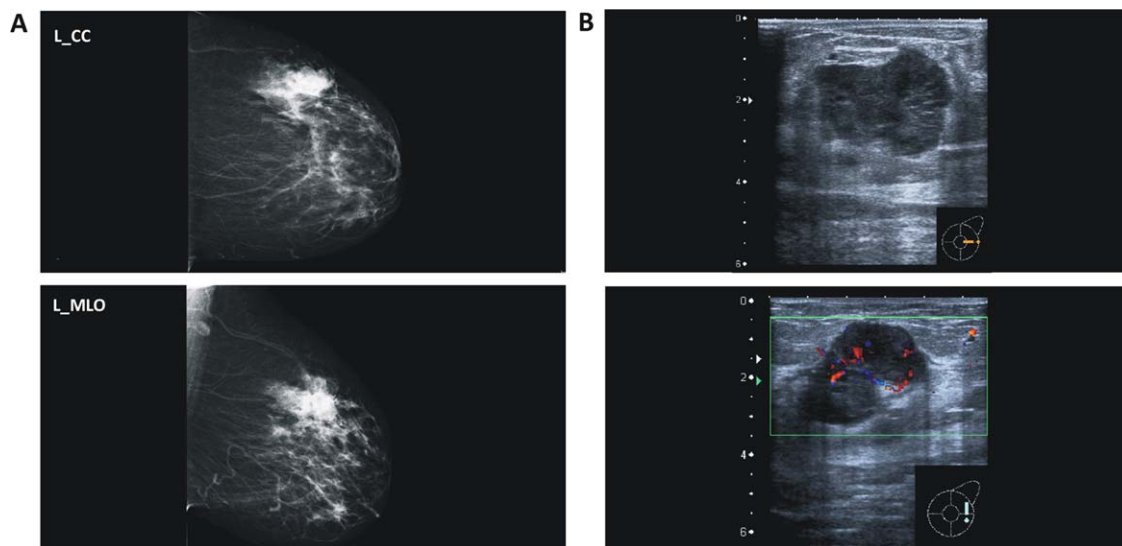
(A) Mammography and (B) Doppler ultrasound showing a highly vascularized mass lesion.
